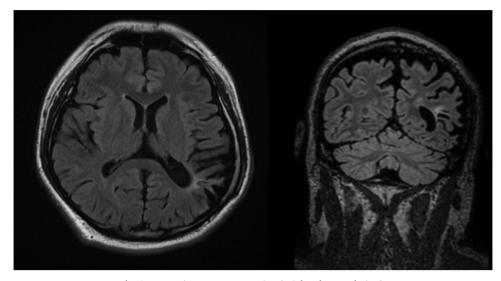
Magnetic Resonance Imaging (axial and coronal view).
